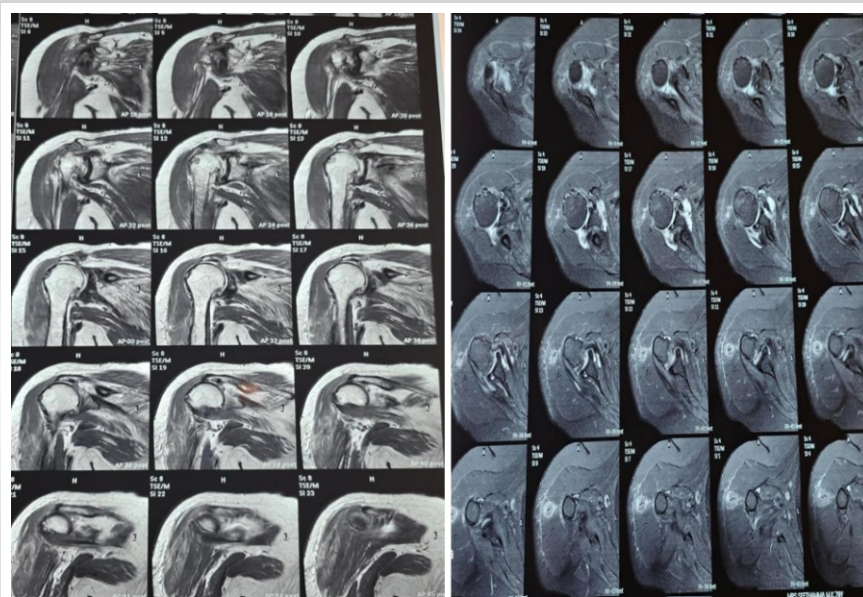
Pre-operative magnetic resonance imaging of the right shoulder demonstrating massive rotator cuff pathology with full-thickness supraspinatus and infraspinatus tears, advanced fatty muscle atrophy, partial subscapularis tear, and associated glenohumeral degenerative changes.
